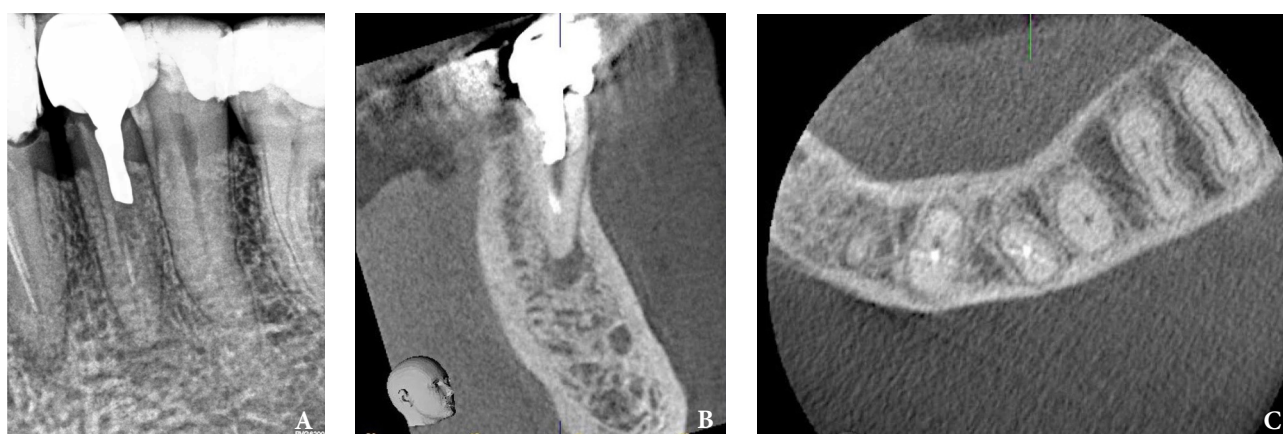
Intraoral radiography showing incomplete endodontic treatment and a periapical lesion on tooth #34 (A). Limited field-of-view (FOV) preoperative CBCT, demonstrating periapical lesion of tooth #34 and an intact buccal cortical plate (B, C). (FIGURE 1 continued on next page.)
